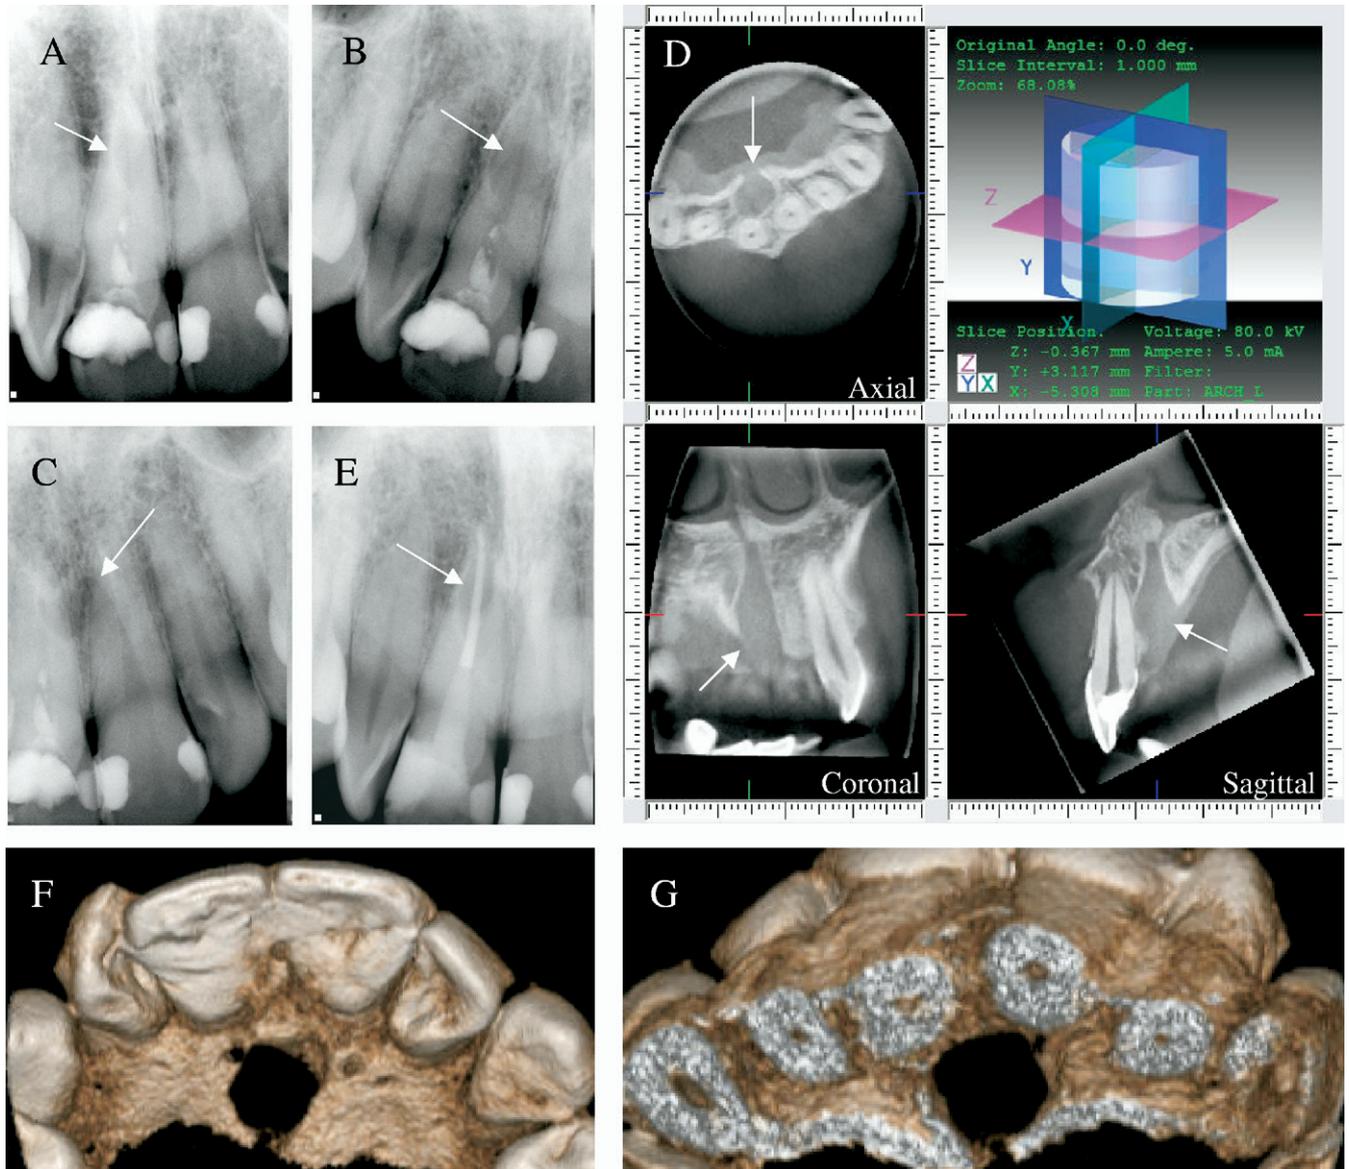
(A) Preoperative periapical radiograph depicts a radiolucent lesion superimposed over the canal in the apical third of tooth #8. (B) Preoperative periapical radiograph exposed from a distal angulation shows the radiolucency moving distally, indicating a lingually positioned lesion. (C) Preoperative periapical radiograph exposed from a mesial angulation shows the radiolucency moving mesially, indicating a lingually positioned lesion. (D) CBVT demonstrates the enlarged incisive foramen in the axial, sagittal, and coronal 2-D slices. (E) Postoperative periapical radiograph depicting the enlarged incisive foramen superimposed over the obturated canal of #8. (F) 3-D CBVT reconstruction of the enlarged incisive foramen by using Accurex processing software (CyberMed International, Seoul, Korea). (G) 3-D CBVT reconstruction of the enlarged incisive canal located mid-root of tooth #8 by using Accurex processing software.
